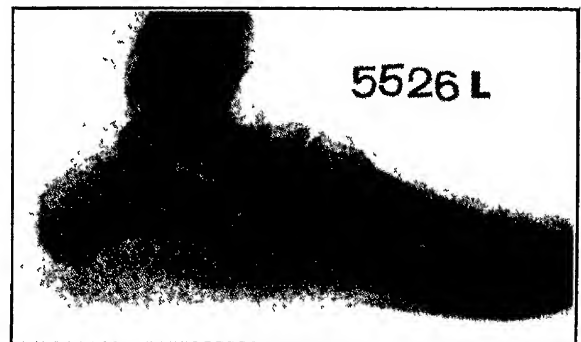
B—Roentgenogram after plantar fasciotomy and anterior-wedge osteotomy. (Cole: J Bone and Joint Surg)
